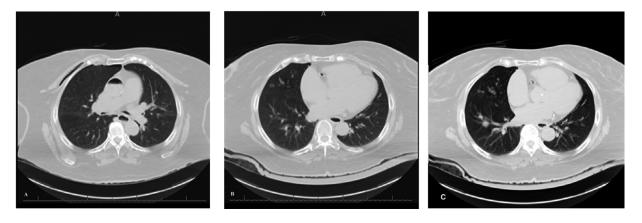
Chest CT. (A) Aortic air embolism. (B, C) Right coronary artery air embolism.
